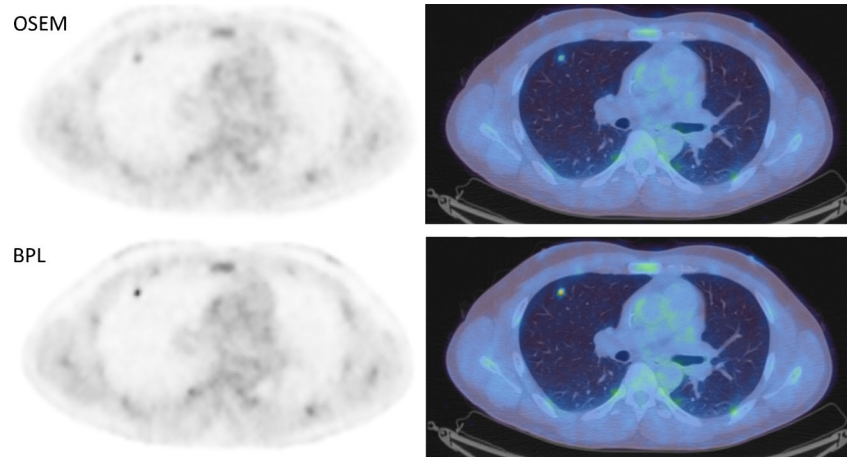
Coronal PET and PET/CT images demonstrating an 11-mm left upper lobe adenocarcinoma which had an SUV_{max} of 2.1 on OSEM, and 4.6 on BPL. Liver and descending aorta SUV_{mean} differed by 0.1 between the two reconstructions. SNR increased by more than twofold from 15 to 35. All PET images are displayed on SUV scale 0–6
